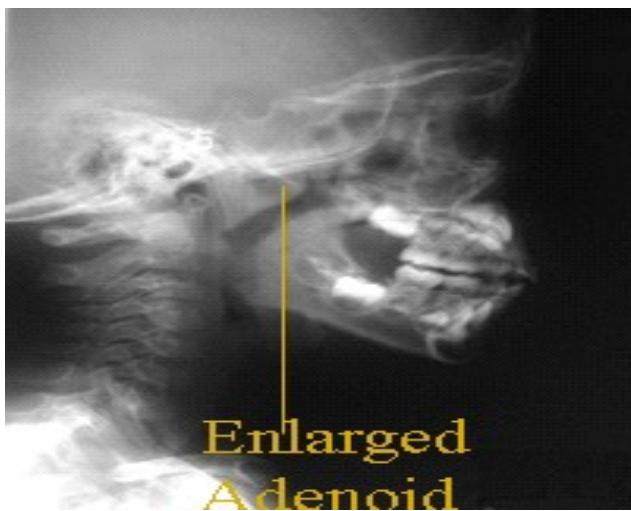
shows enlarged adenoid on x-ray of postnasal space.
